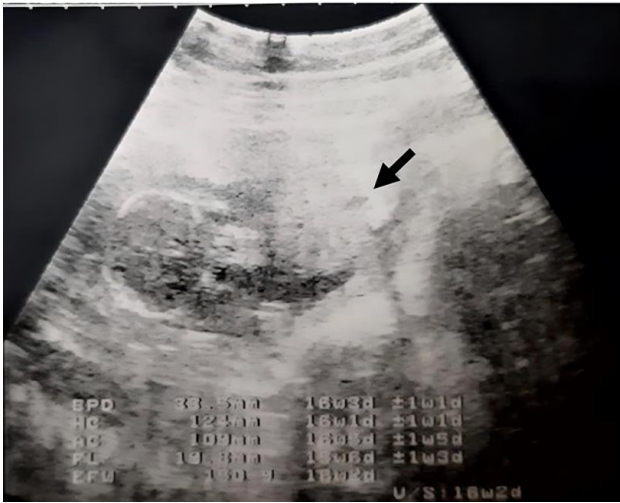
Grayscale ultrasonographic image showing anterior low-lying placenta (black arrow) (reprinted with permission of the patient)
